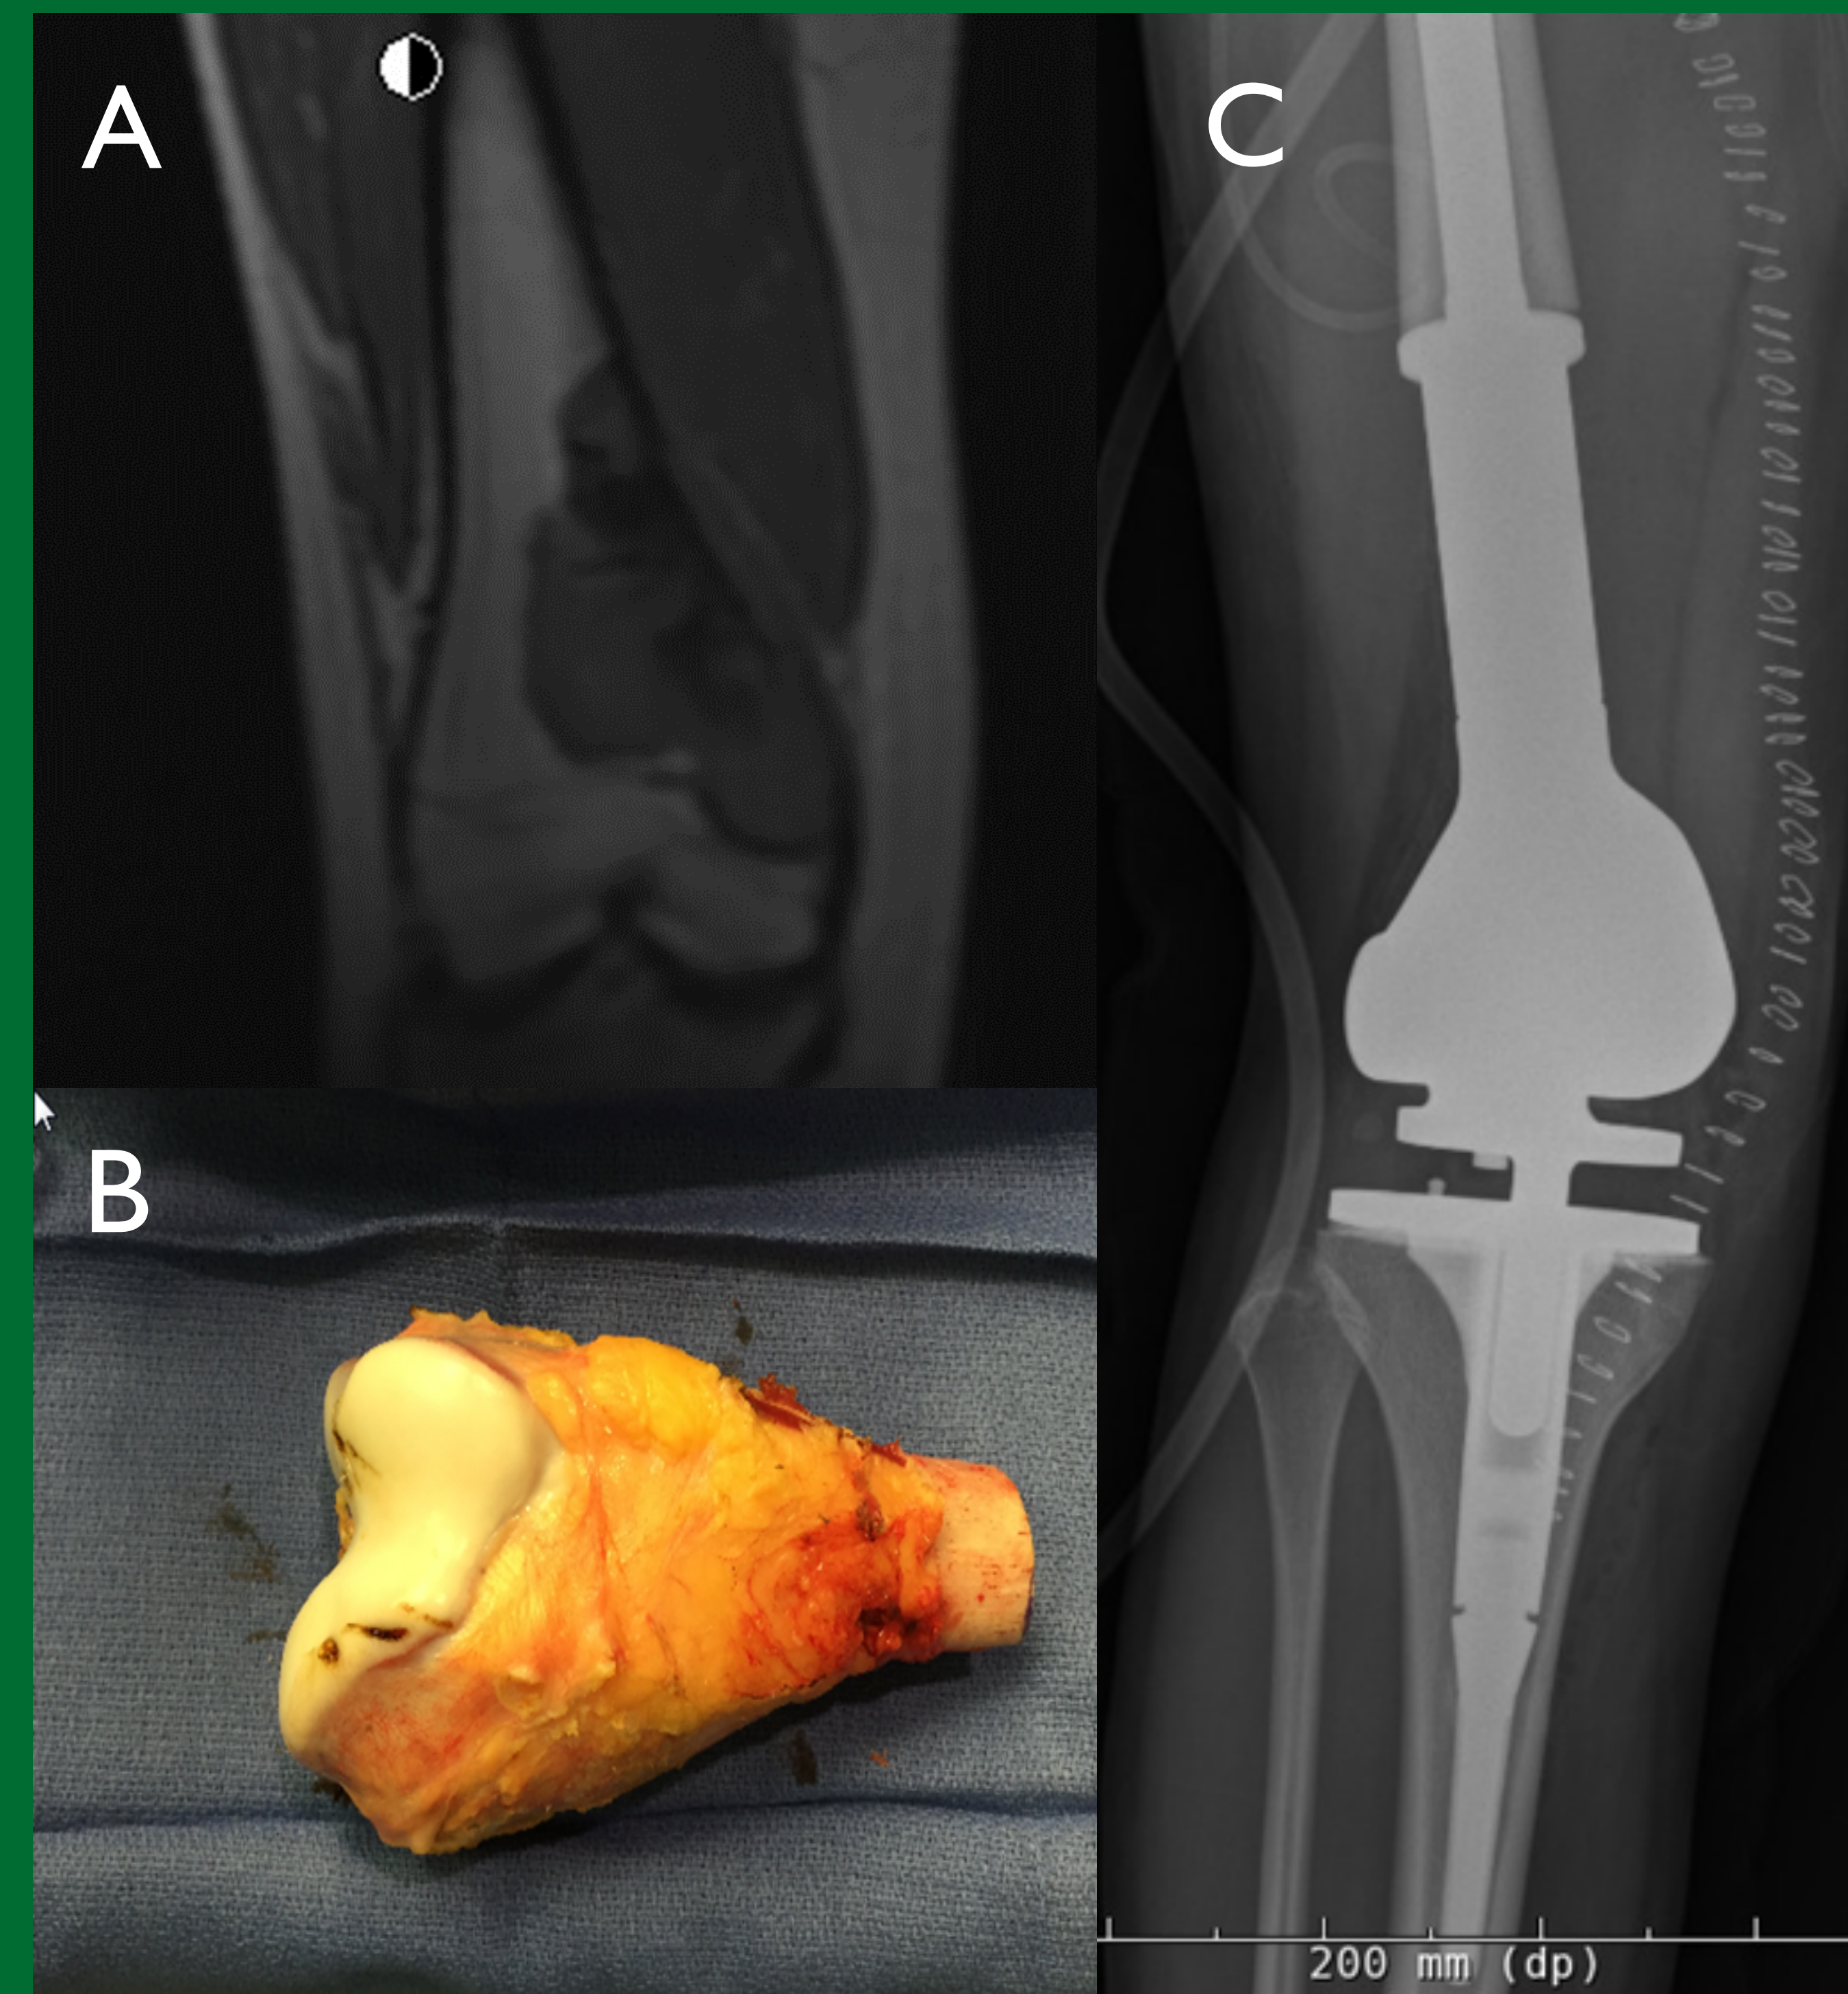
MRI (A) of distal femoral osteosarcoma (B) in a 13-year-old who was reconstructed with a modular endoprosthesis (C).
